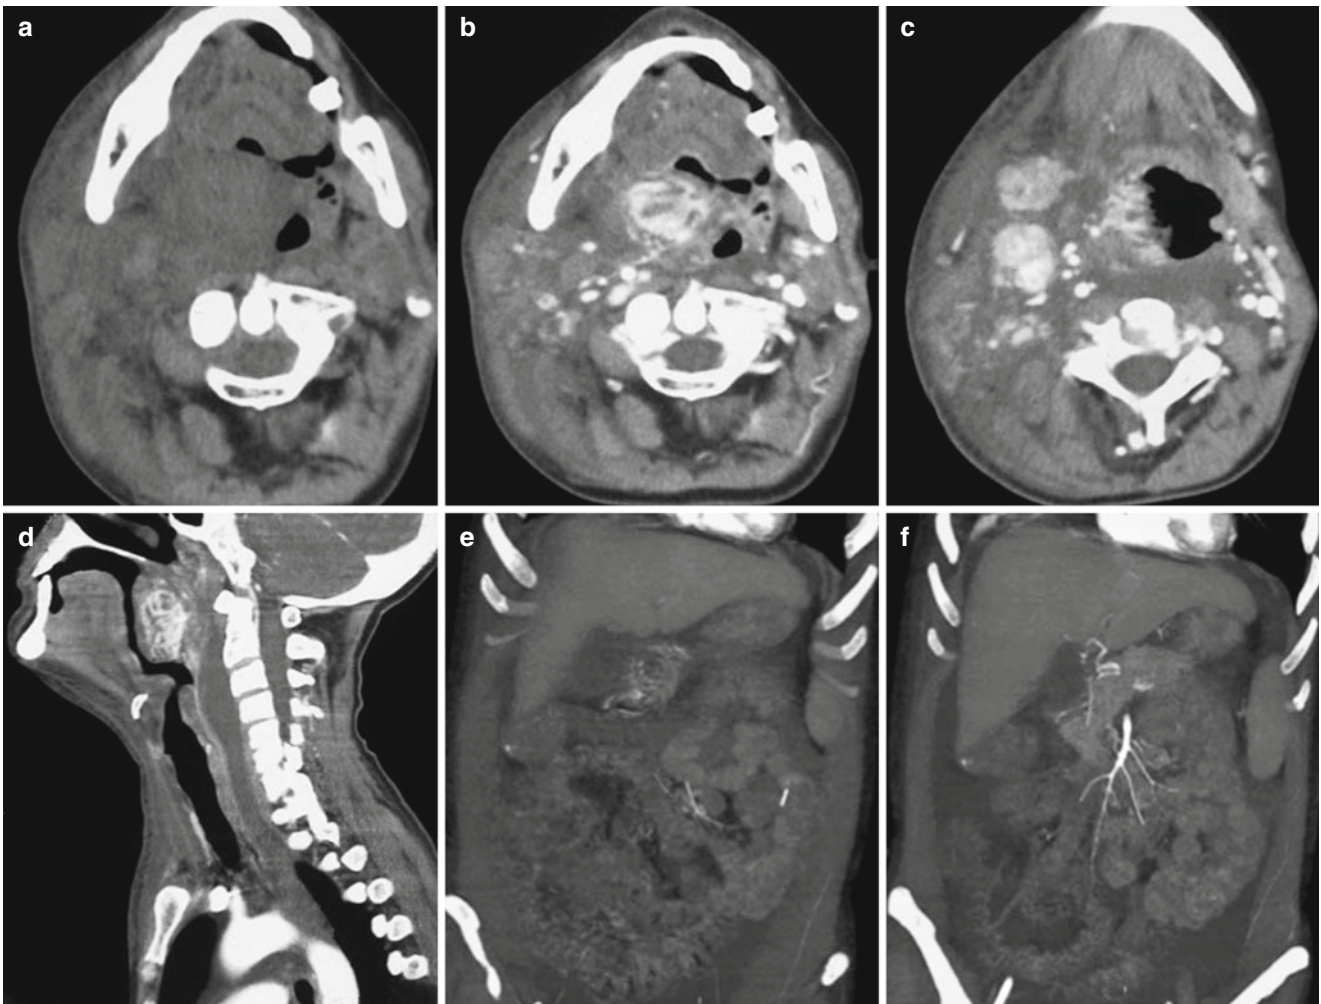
Gastrointestinal anthrax. (a–d) Oropharyngeal anthrax. (a) Plain CT scanning of the neck demonstrates obvious swelling of the cervical soft tissues and narrowed cavities of nasopharynx, oropharynx, and laryngopharynx. (b) Enhanced scanning demonstrates multiple enlarged lymph nodes within lesions and the neck as well as uneven enhancement. In some cases, necrosis and liquefaction can be found. (c) Inflammatory changes can be found around the lymph nodes. (d) Fluid
